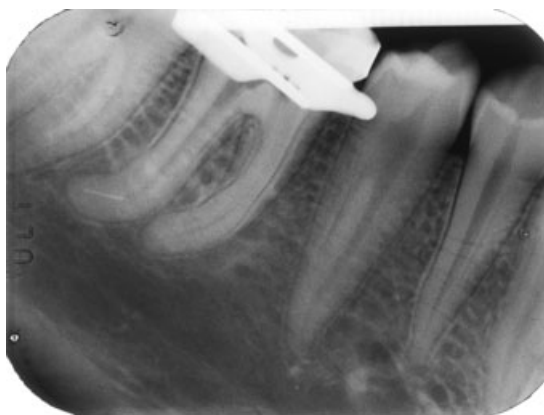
Radiograph showing a fractured 25/0.02 RaCe rotary file in the distobuccal canal.
